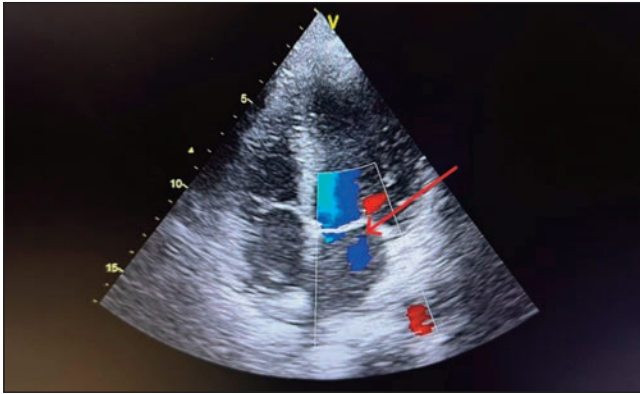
Post-Op Four chamber Echocardiography showing no myxoma with clear margins.
